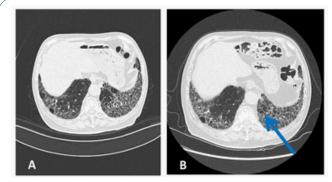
Progression of ILA: CT examination obtained in a 76 years old male, CT images in 2017 (A) CT showed subpleural reticular pattern, ground-glass opacity and traction bronchiectasis; (B) CT obtained 4 years later showed ground-glass shadows have increased significantly at left lower lobe (arrow).
